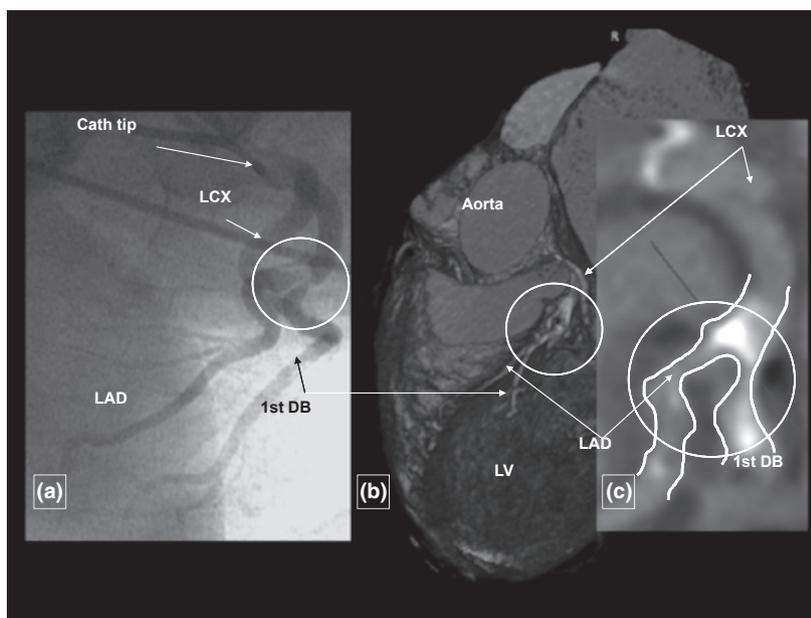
Significantly diseased vessel segment. In this case significant diseased mid LAD at the passing region of the diagonal branch, which itself appears significantly diseased in his proximal portion is clearly depicted by ICA (Image a) and CTA VRT image reconstruction (Image b) with additional longitudinal MPR and vessel contouring (Image c). This 66-year-old male patient 11 years after heart transplantation underwent stent implantation procedure. Note that in this case calcified tissue which is not impairing evaluation of vessel lumen causes the stenosis. Calcified plaques were rarely found in our study population. DB: diagonal branch; LAD: left anterior descending coronary artery; LCX: left circumflex coronary artery.
